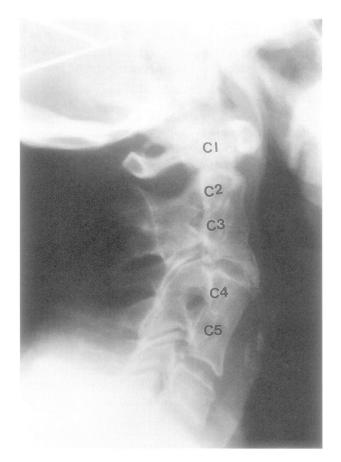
Vertebral fusion. Lateral cervical radiograph of IV-10 showing the C2-3 and C4-5 fusion.
